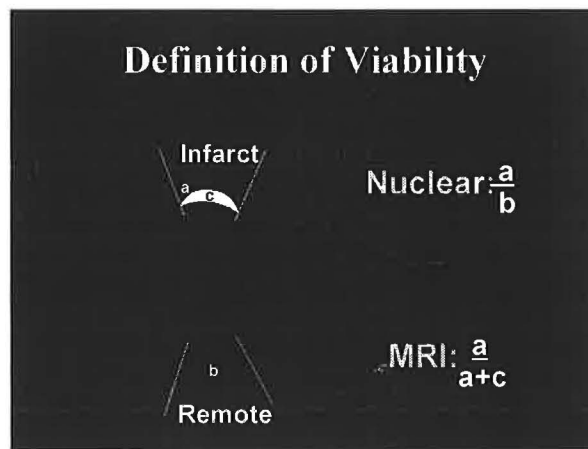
Definition of viability by nuclear and MRI represent different concepts as shown.
